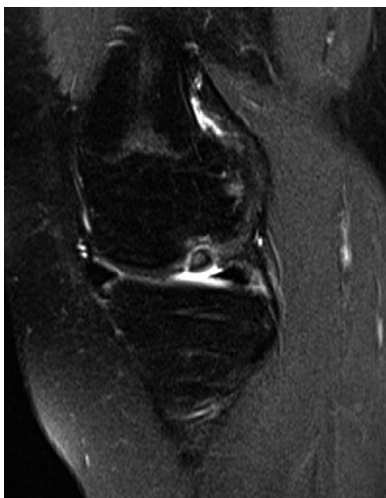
MRI scan knee sagittal T2 view
